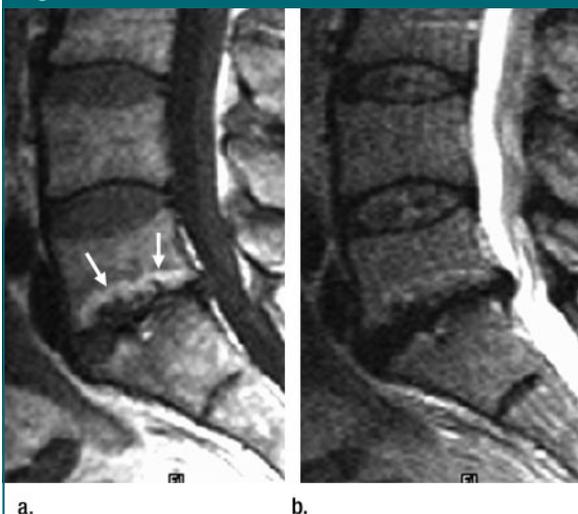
Degenerative type II vertebral body marrow changes. (a) Sagittal midline T1-weighted SE (450/12) image demonstrates degenerative changes of L5-S1 disk space and high signal intensity (arrows) in adjacent vertebral body marrow. (b) T2-weighted SE (4000/120) image shows that marrow signal intensity adjacent to degenerated L5-S1 disk is now only slightly hyperintense relative to more normal marrow.
